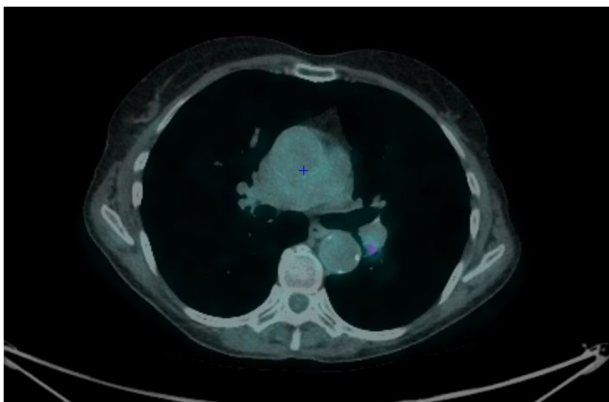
Fused PET-CT image revealing mild metabolic activity in the hilar region (SUV max 4.4), with no uptake in the pulmonary nodule itself.
